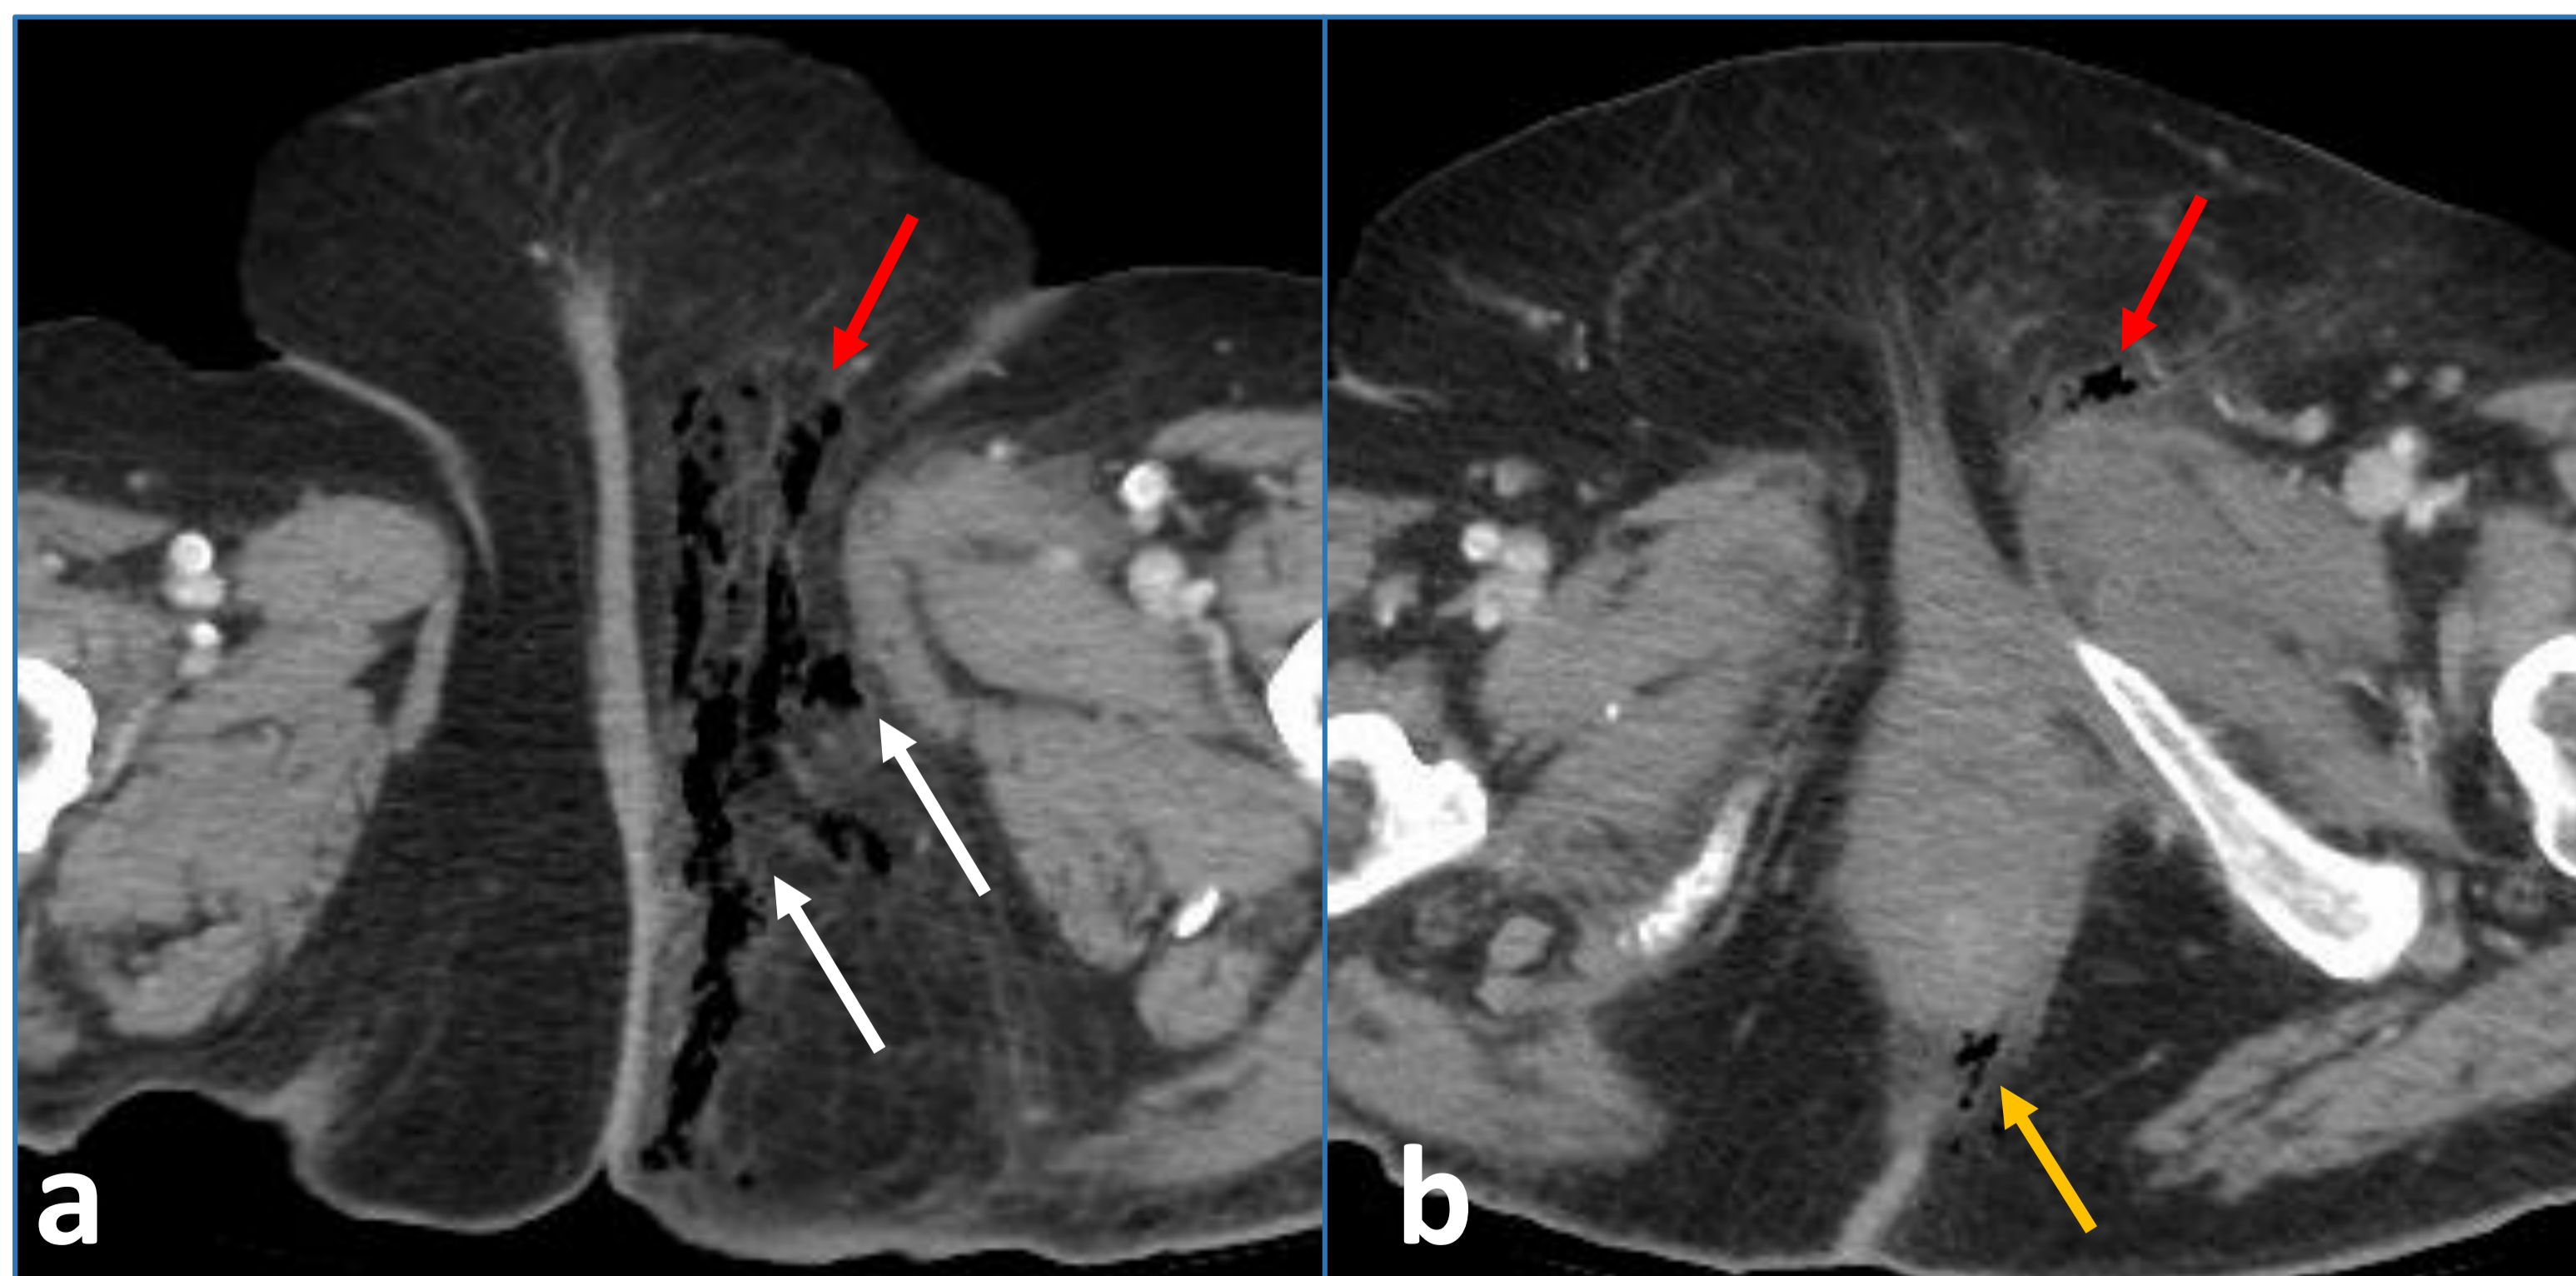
Fournier's gangrene in female. a, b axial CT images show fat stranding and soft tissue gas at left-sided perineum (arrow) with extension to left labia majora (red arrow) and left ischioanal fossa (yellow arrow).
